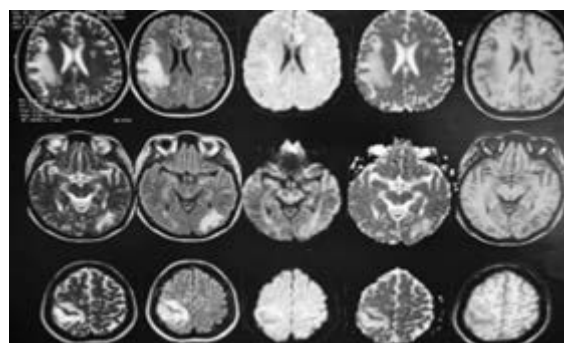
Brain MRI scan from 2019 hospital admission showing multiple extensive bilateral inflammatory lesions with a pseudo-tumoral appearance.
